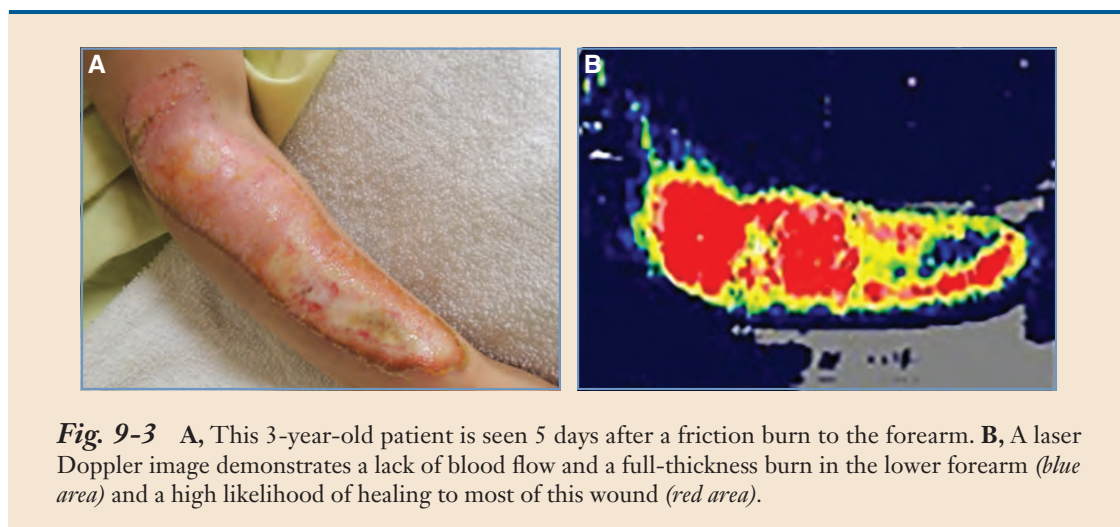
A, This 3-year-old patient is seen 5 days after a friction burn to the forearm. B, A laser Doppler image demonstrates a lack of blood flow and a full-thickness burn in the lower forearm (*blue area*) and a high likelihood of healing to most of this wound (*red area*).
